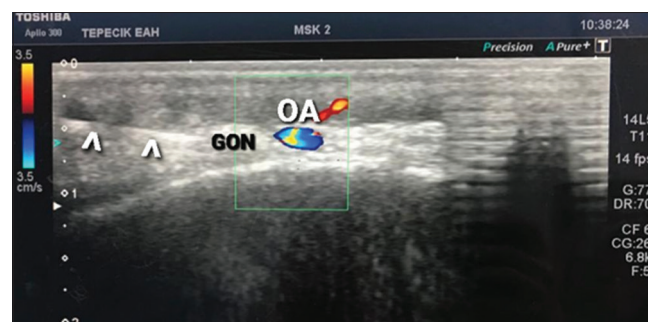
Ultrasound-guided greater occipital nerve (GON) block at distal level with in-plane technique from medial to lateral. GON is localized medial of the occipital artery. GON: greater occipital nerve OA: occipital artery, arrowheads: block needle
